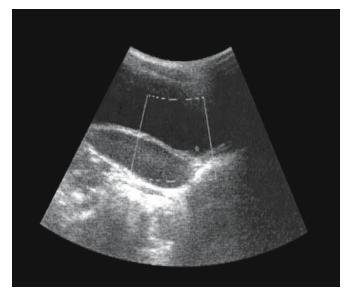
Ultrasound scan shows conical narrowing of the left lower ureter in a 2-year-old child
